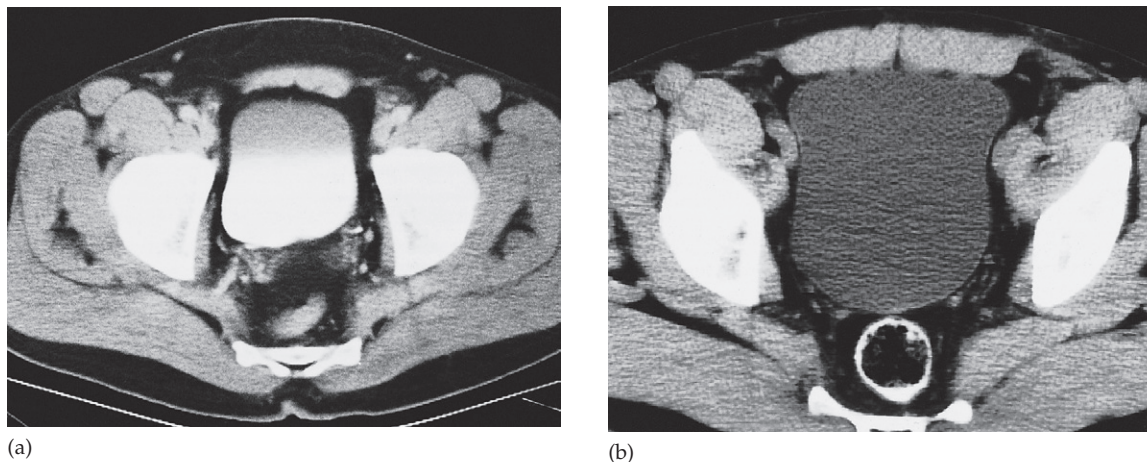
(a) CT section through an opacified bladder in a male patient showing that the bladder wall is too thin to be seen. Note the layering of contrast medium. (b) Section through a bladder without contrast opacification. The bladder wall can be identified as a thin line.
